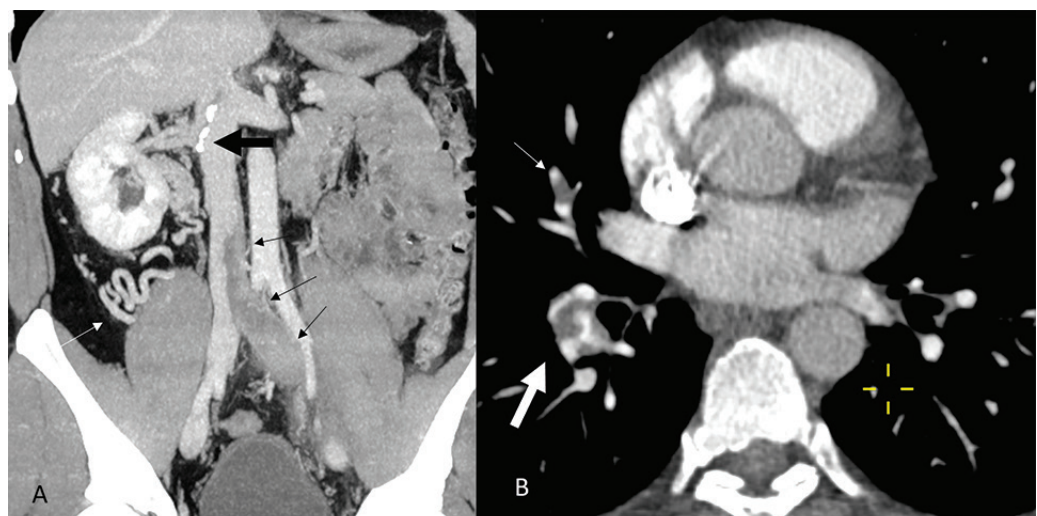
Computed tomography venography showing acute left ilio caval thrombosis (black thin arrows). Amorphous calcification in the lumen of the pararenal inferior vena cava and ostium of the right renal vein (black thick arrow) accompanied by venous collaterals around the left kidney (white arrow) suggesting prior thrombosis (A). Acute emboli in the right lobar (thick arrow) and segmental (thin arrow) pulmonary arteries (B).
